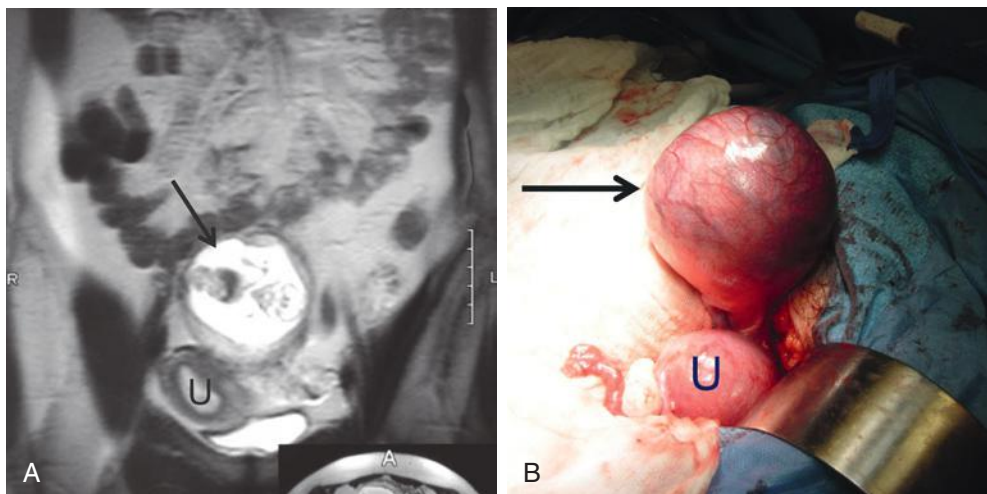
Pregnancy within the rudimentary horn of a unicornuate uterus. A, Coronal T2-weighted magnetic resonance image of the pelvis shows the uterus (U) and an adjacent ectopic pregnancy (*arrow*) containing a 10-week fetus. The pregnancy appears attached to the uterus. B, Intraoperative photograph showing the uterus (U) and the adjacent ectopic pregnancy (*arrow*), which was located in a rudimentary horn attached to a unicornuate uterus. The ectopic pregnancy was excised without incident.
